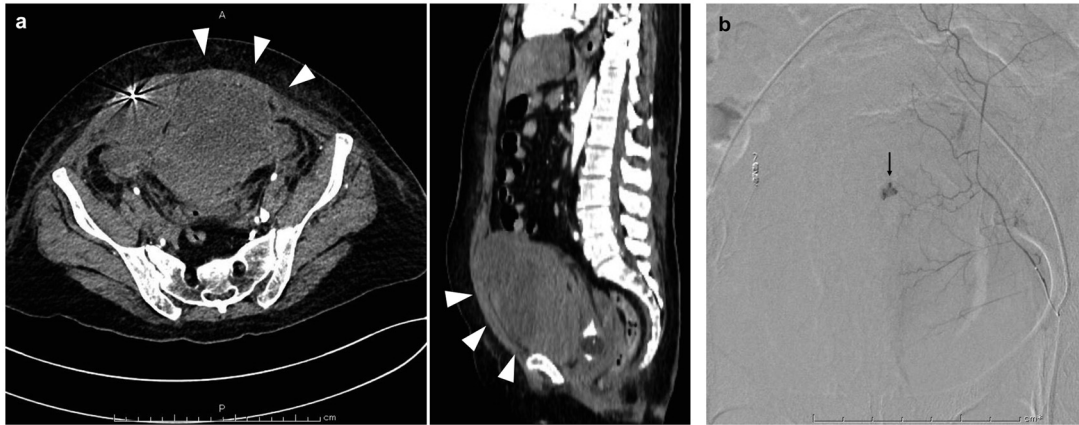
A: Enhanced abdominal computed tomography reveals a mass in the left abdominal wall (white arrowhead). (B) Selective angiogram shows bleeding (black arrow) from the left inferior epigastric artery.
